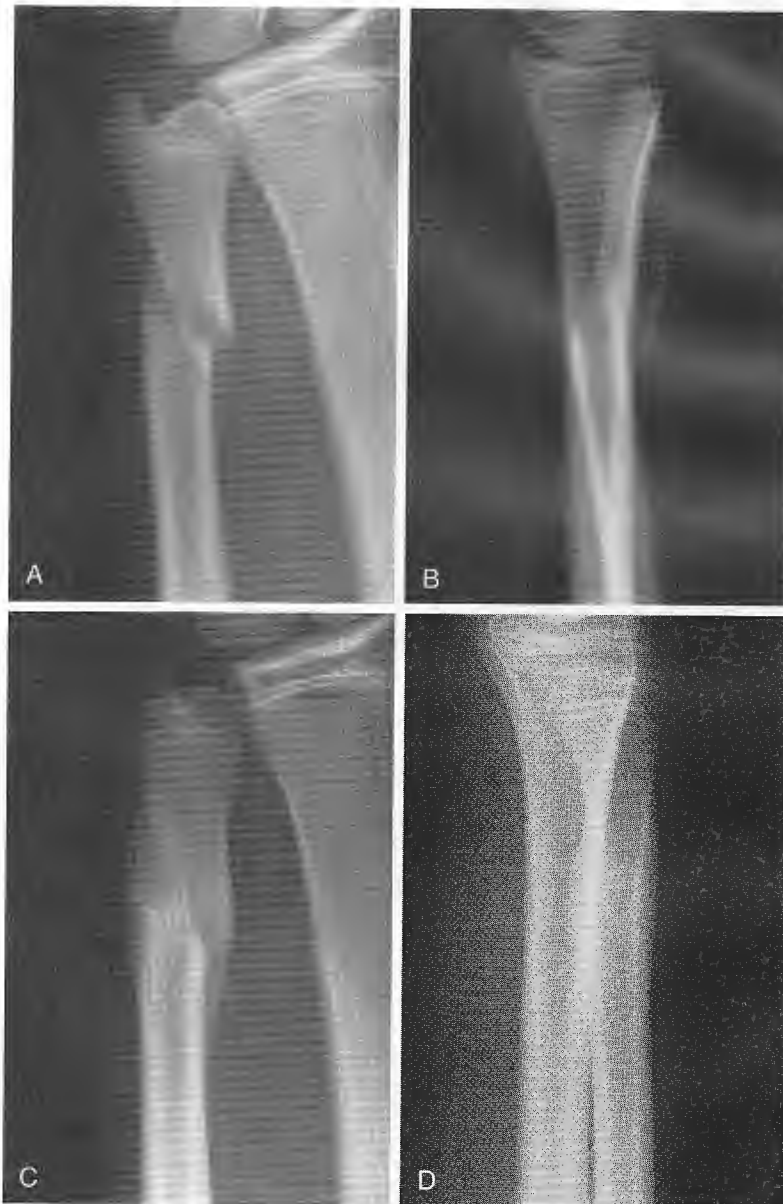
The baseball athlete slid into first base and complained of wrist pain. Anteroposterior (A) and lateral (B) radiographs show a dorsally dislocated distal ulna with displaced fracture. Anteroposterior (C) and lateral (D) views at 2 months follow-up show healed fracture.
